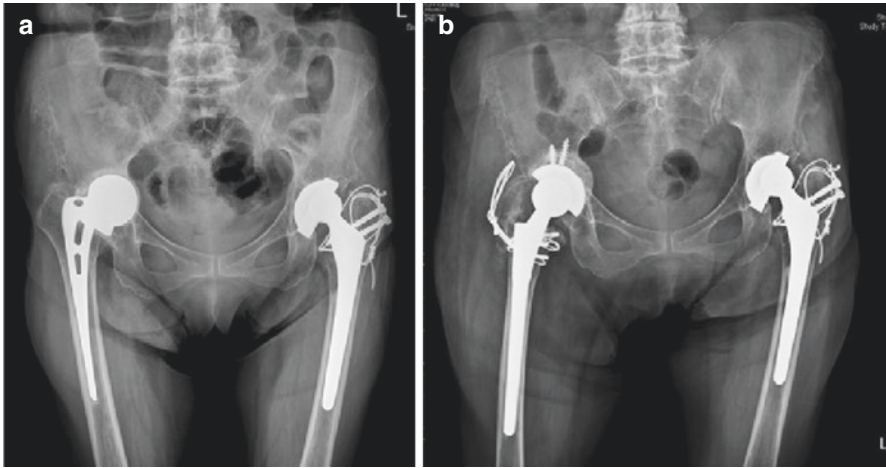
A 75-year-old woman with a central protrusion of Moore endoprosthesis which was implanted in the right hip 38 years previously. Radiograph showed a Paprosky type IIC acetabular defect (a). One year after revision of THA using an uncemented acetabular component and impacting allograft, the medial defect shows well-fixed cup to the acetabular rim and consolidation of the morselized allografts (b) (these pictures were agreed by the patient for publication)
